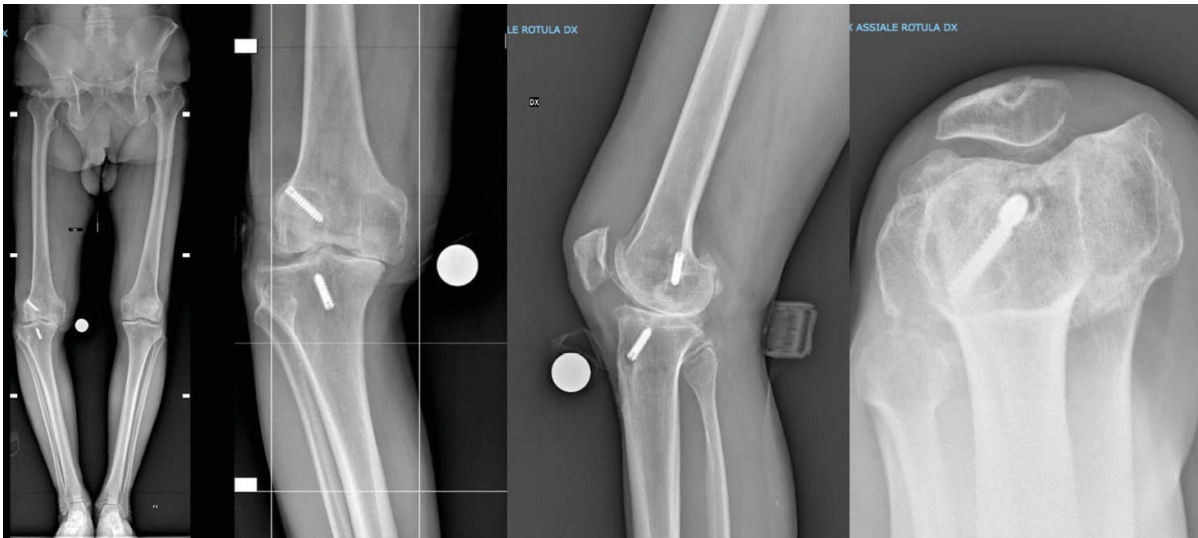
Preoperative X-rays of a 51-year-old male patient with osteoarthritis of the right knee and a prior anterior cruciate ligament reconstruction performed 29 years ago. The preoperative range of motion was 0-105°, with lateral thrust.
